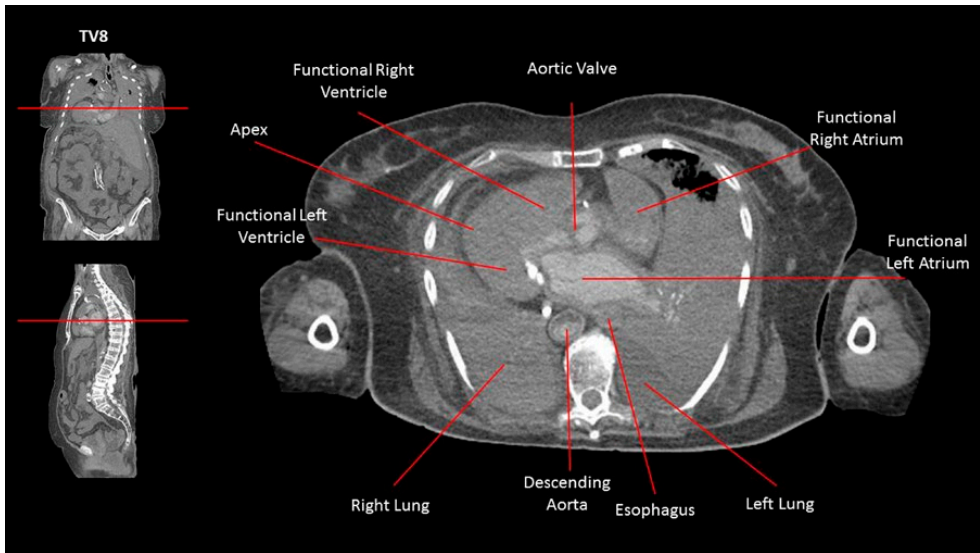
CT imaging of the heart chambers at the thoracic vertebral level 8 (TV 8). The functional right atrium and functional right ventricle are the most anterior chambers located posterior to the sternum. The functional left atrium is located just anterior to the descending aorta and esophagus. The functional left ventricle with its apex of the heart is directed towards the right. The descending aorta can be seen to the right of the vertebral column while the esophagus is located just left of the midline. The red lines in the coronal and sagittal images denote the vertebral level.
